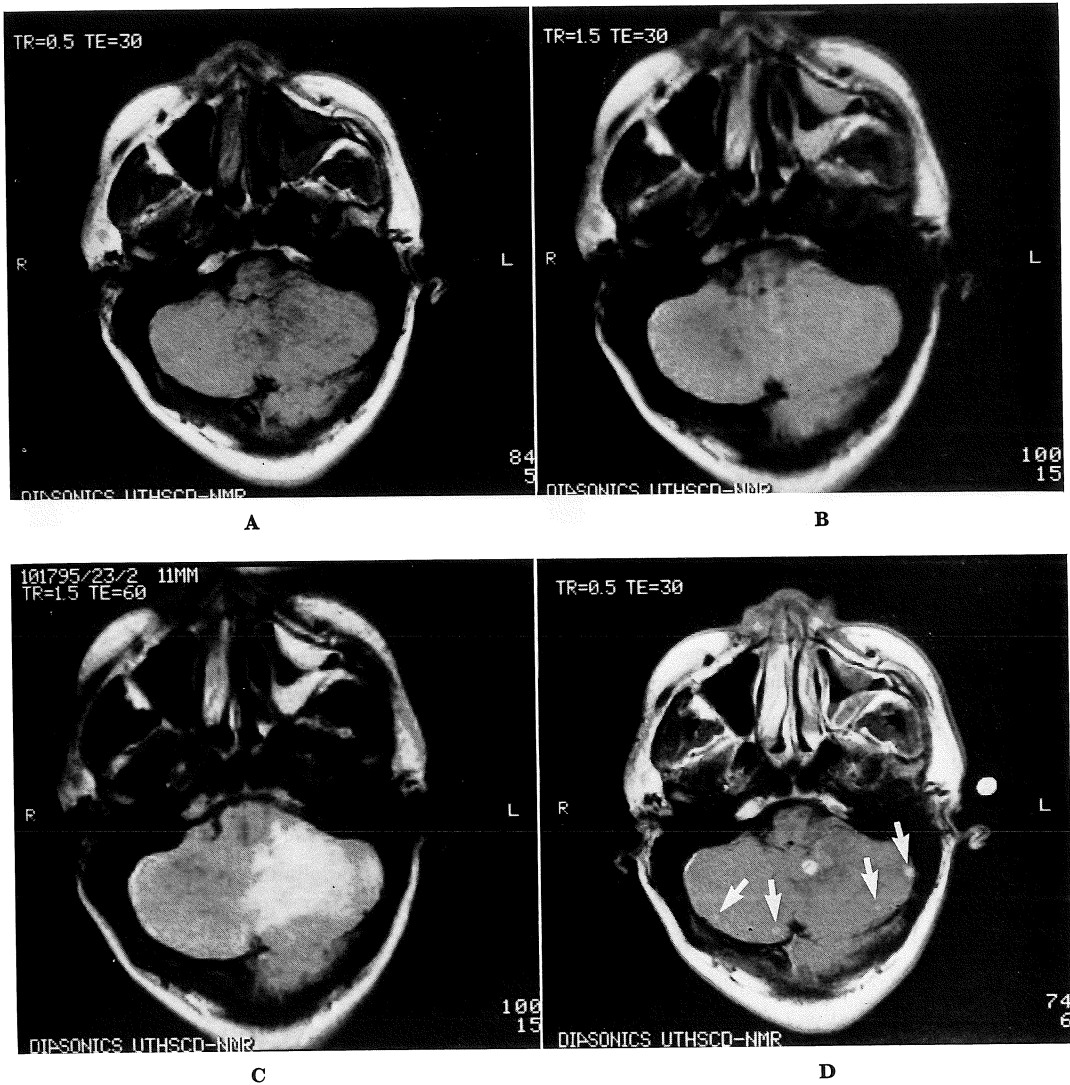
Pre-contrast MR images of the posterior fossa
